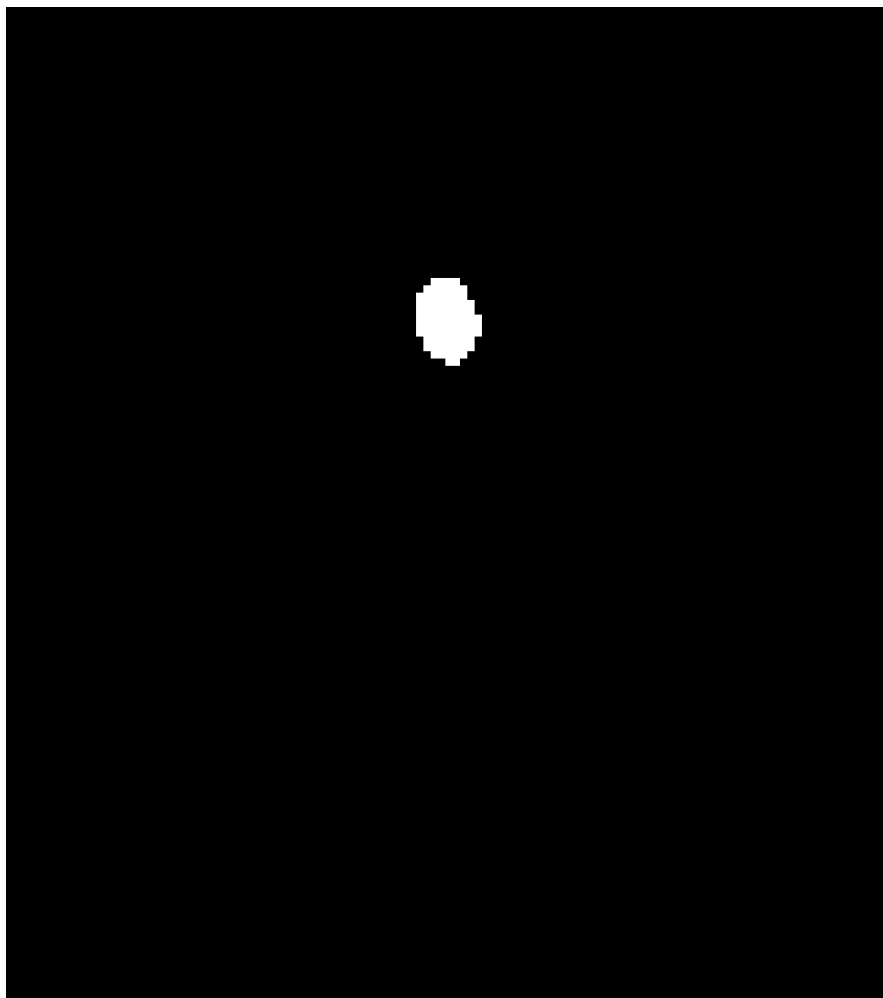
A segmented (in the non-deformed pre-operative/pre-interventional MRI image) ROI MLPs 2D cross section mapped to grayscale.
